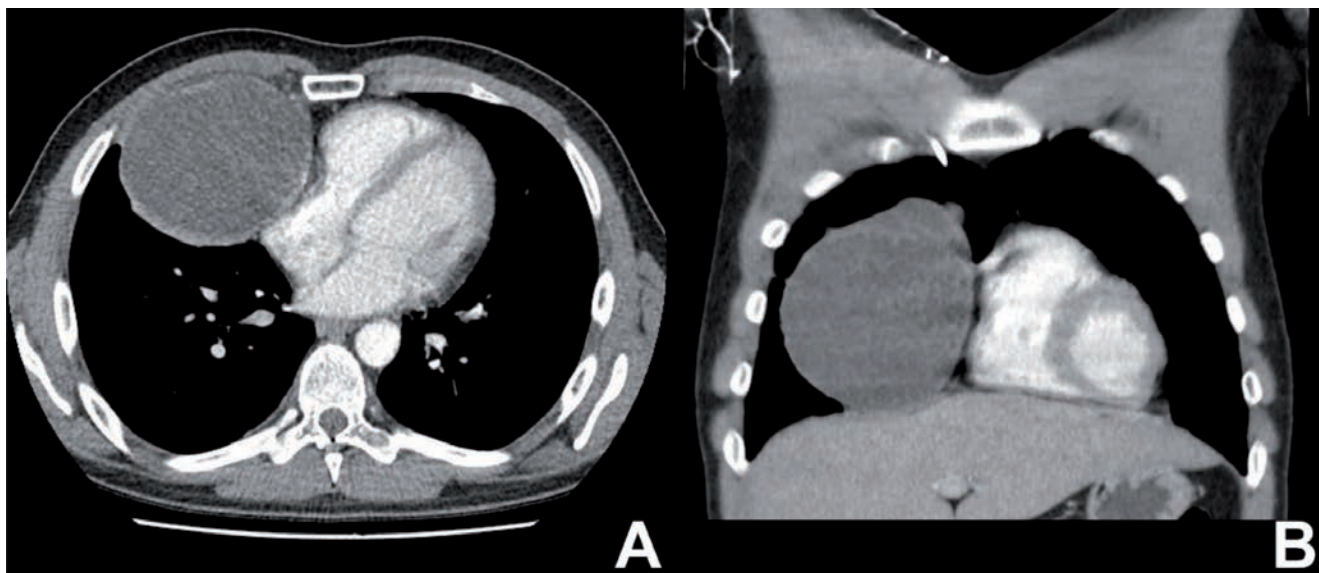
The preoperative computed tomography scan shows the right paracardial hypodense tumor in the axial (A) and coronal (B) plane.
